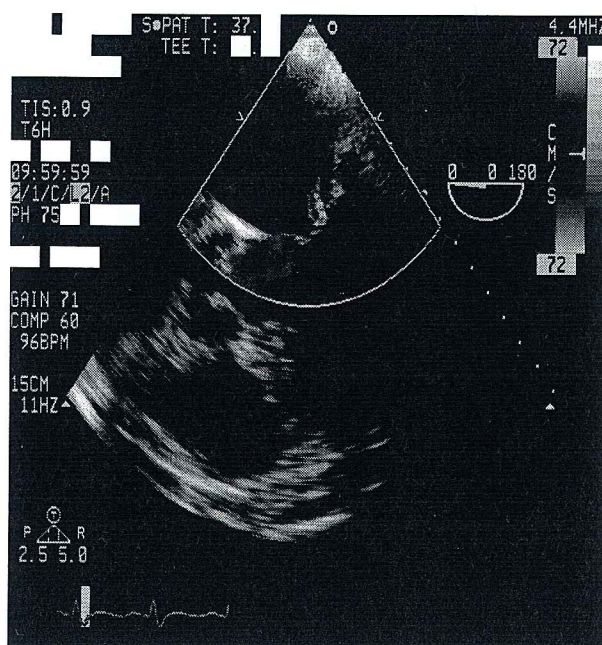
Standard cardiac B-mode ultrasound image with Doppler color overlay and burned-in information masked.
